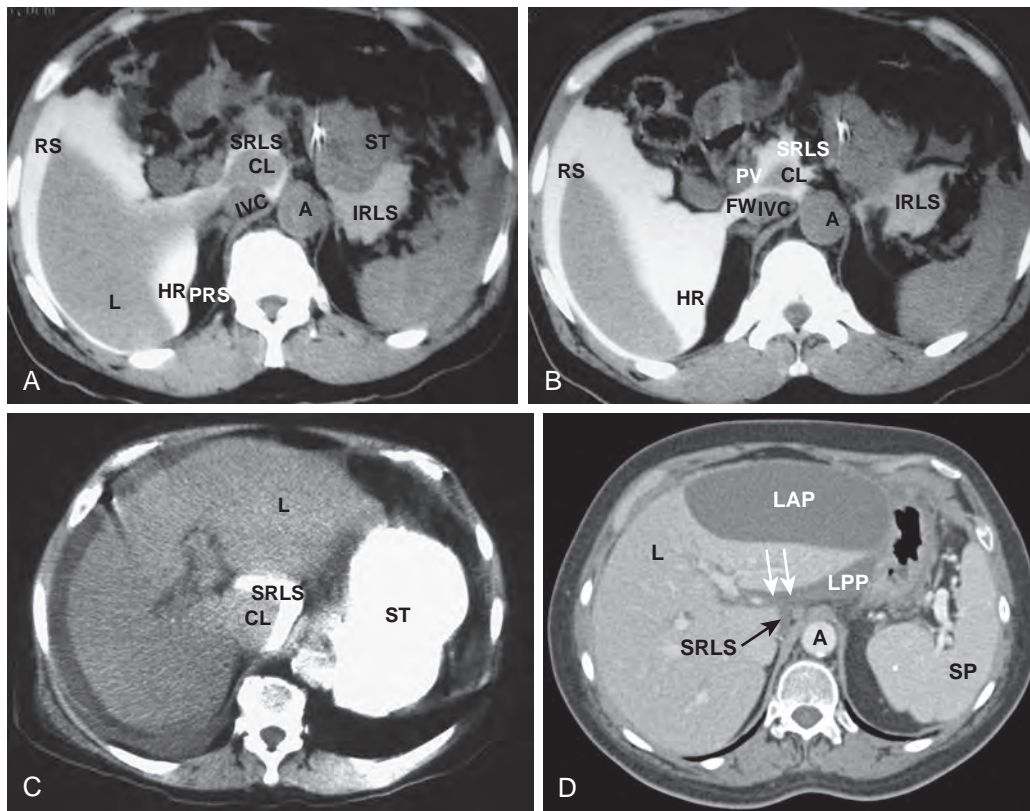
The foramen of Winslow. A. In a patient with peritoneal bladder perforation from trauma, CT shows contrast material from CT cystography filling the right subphrenic space (RS) around the liver (L) and flowing into the hepatorenal recess (HR) between the liver and the perirenal space (PRS). Some of this contrast material has extended into the two compartments of the lesser sac. The denser collection lies within the superior recess of the lesser sac (SRLS), surrounding the caudate lobe (CL), and the more dilute collection is in the inferior recess of the lesser sac (IRLS), posterior to the stomach (ST). B. CT section 15 mm inferior to that in A shows hepatorenal recess fluid (HR) funneling into the superior recess of the lesser sac (SRLS) through the narrow foramen of Winslow (FW), which lies between the inferior vena cava (IVC) and the portal vein (PV). The aorta (A), caudate lobe (CL), and inferior recess of the lesser sac (IRLS) are identified. C. CT section in another patient who proved to have a perforated gastric ulcer shows dense contrast material leaking from the lumen of the stomach (ST) into the superior recess of the lesser sac (SRLS), defining its characteristic boomerang shape on the medial surface of the caudate lobe (CL). The liver (L) is identified. D. CT section in a patient with ascites shows the relationship between the collection in the left posterior perihepatic space (LPP) and the smaller collection in the superior recess of the lesser sac (SRLS). Between the two collections lies the gastrohepatic ligament (arrows). The aorta (A), liver (L), stomach (ST), and spleen (SP) as well as a tense collection in the left anterior perihepatic space (LAP) also are identified.
